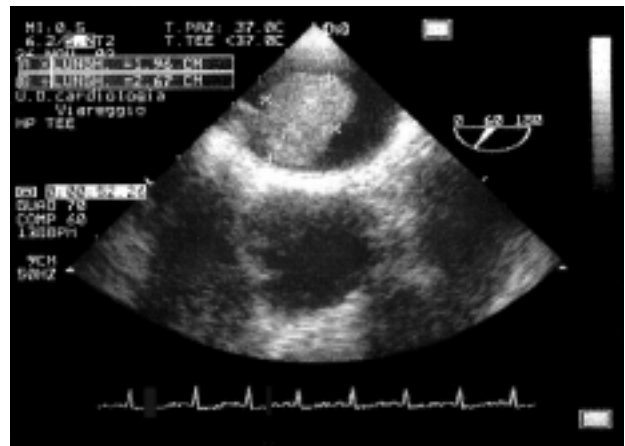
Case 2. Transesophageal echocardiogram: evidence of a left atrial mobile mass attached to the fossa ovalis with a pedicle.
